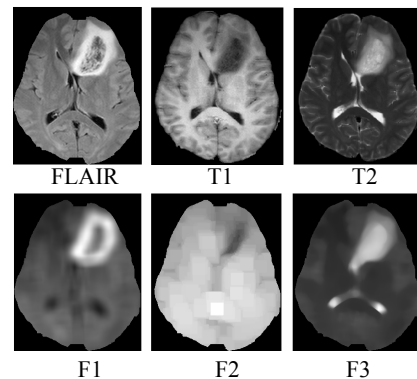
Original MR images(upper line) and 3 most effective features selected by AdaBoost  $F1$ ,  $F2$  and  $F3$ (lower line)
